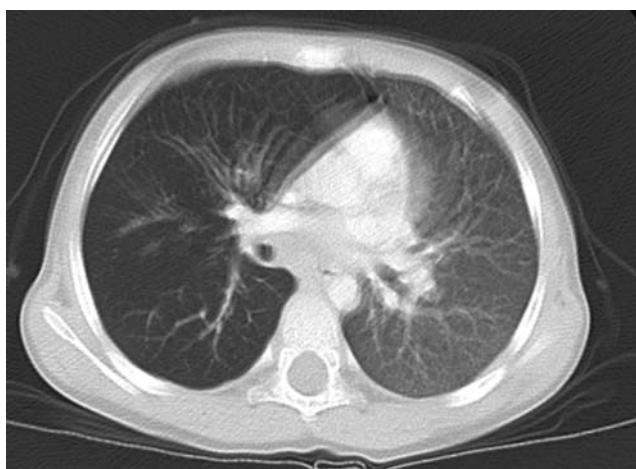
Axial CT shows the hyperaeration of the right lung
